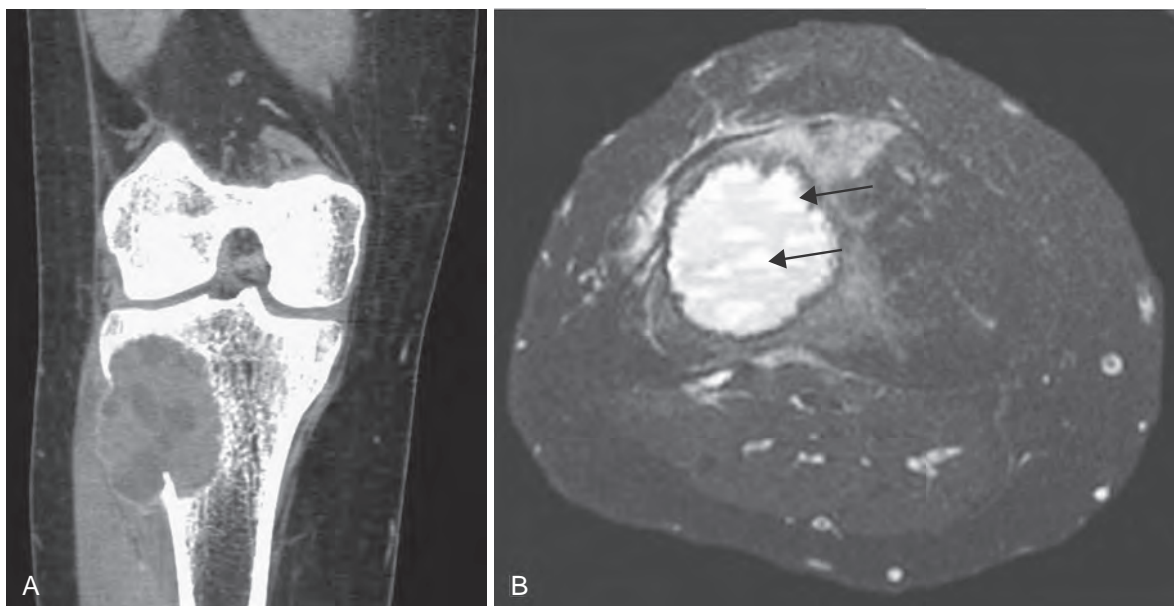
(A) Coronal computed axial tomography scan showing an eccentric aneurysmal bone cyst of the tibia. The soft tissue component is delineated by a thin rim of reactive subperiosteal bone. (B) Axial magnetic resonance image demonstrating characteristic fluid levels (arrows).
